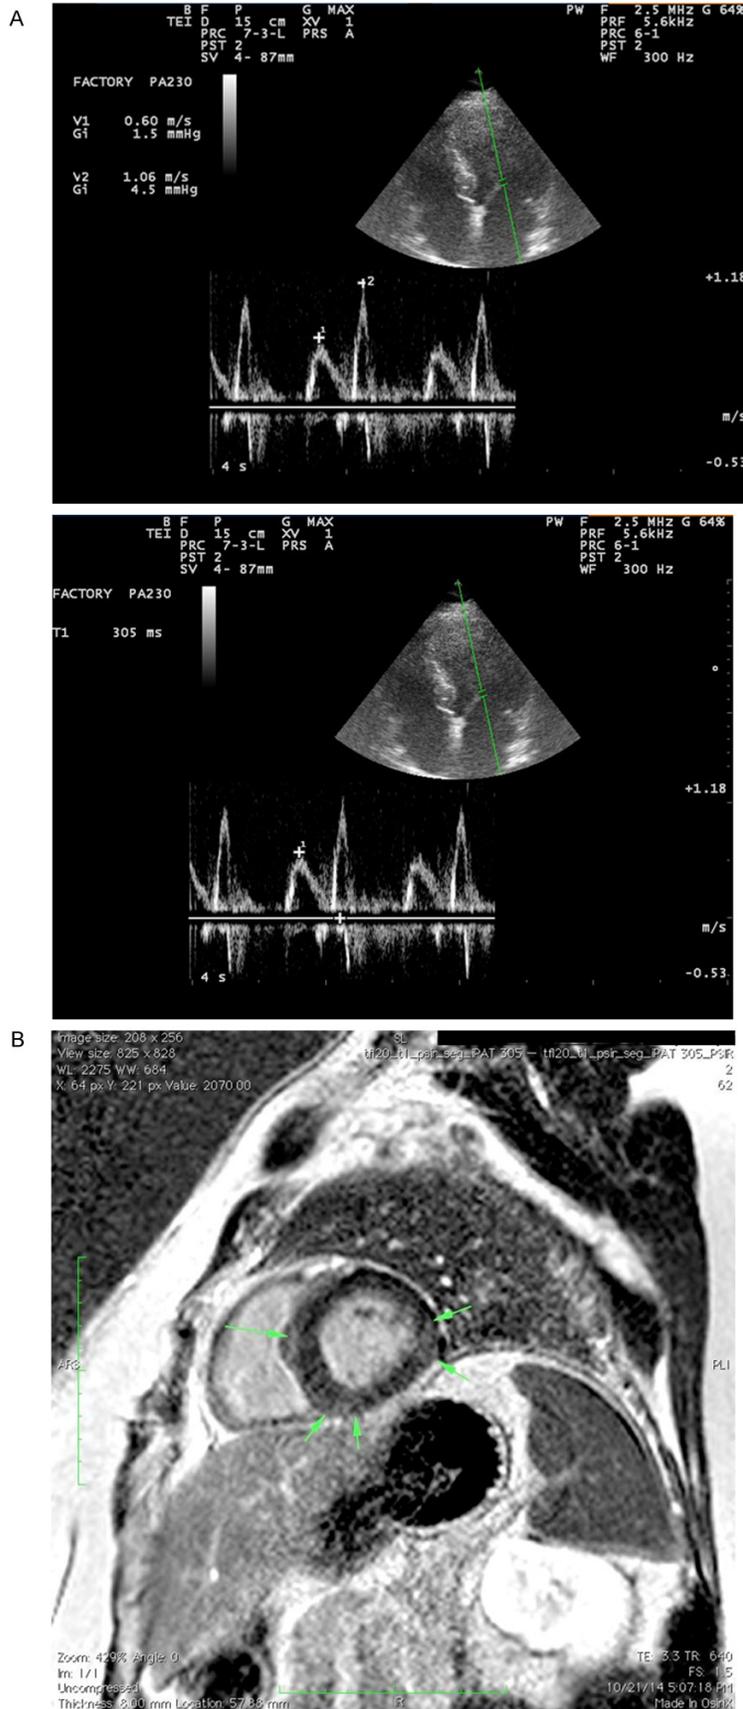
Transthoracic echocardiographic images (A) and cardiac DE-MRI (B) of a patient with limited scleroderma. The echocardiographic images show the amplitude of the E wave (m/s) and A wave (m/s), with a decreased E/A ratio of 0.56 (first echocardiographic image) and prolonged E deceleration time (second echocardiographic image), compatible with the presence of diastolic dysfunction (impaired relaxation of the left ventricle). The Em/Am ratio in this patient was 0.45 (not shown). The DE-MR image (lower panel) shows the presence of extensive intra-mural fibrosis (green arrows).
